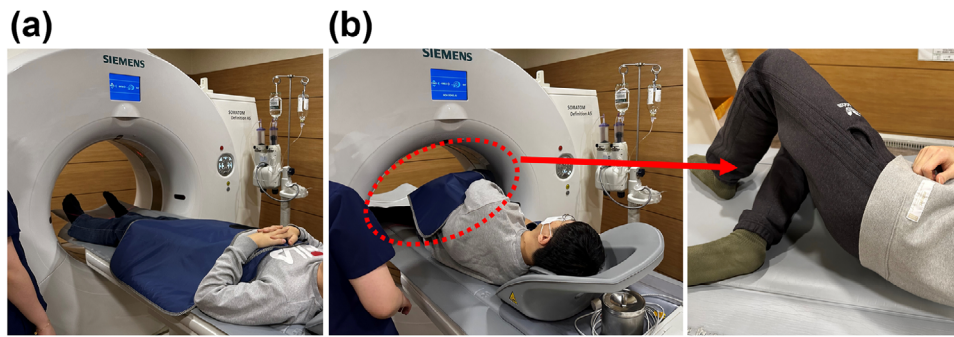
CT scan environment of the knee. (a) Extension state. (b) Flexion state.
